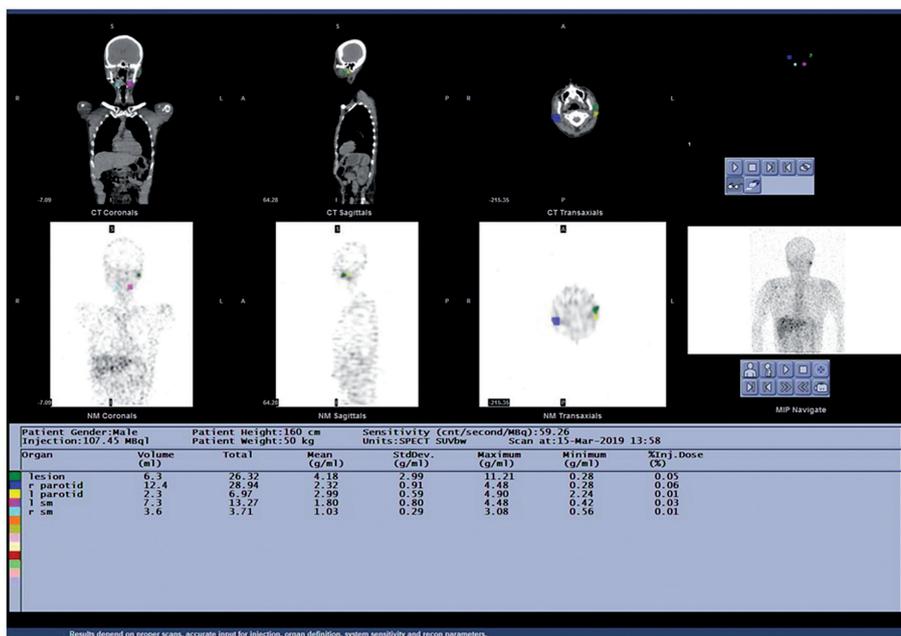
Malignant lymphoma of the left side of the neck in a 54-year-old male. By using the transaxial single-photon emission tomography (SPECT) and computed tomography (CT) as the anatomical reference, a volume of interest (VOI) was drawn over the lesion (green), right parotid gland (blue), left parotid gland (yellow), right submandibular gland (sky blue), and left submandibular gland (pink). The dosimetry software provided multiple quantitative data for a given VOI
